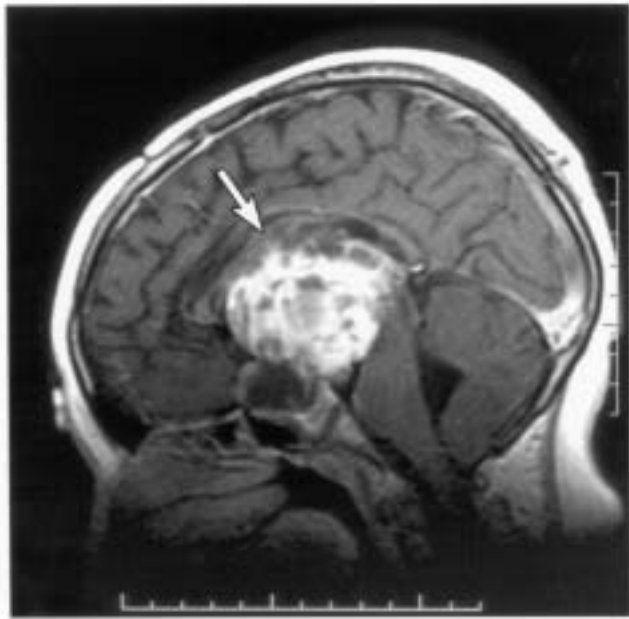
The MRI for patient #3 is shown. The sagittal, T1-weighted, contrast enhanced magnetic resonance image demonstrates a large suprasellar mass, which is a recurrent hypothalamic-optic nerve astrocytoma (arrow). The mass extends into the sella inferiorly and displaces the floor of the third ventricle. The superior aspect of the brainstem is displaced posteriorly. Mild obstructive hydrocephalus of the lateral ventricles is evident, but relatively decompressed with a ventriculo-peritoneal shunt (not seen on this image).
